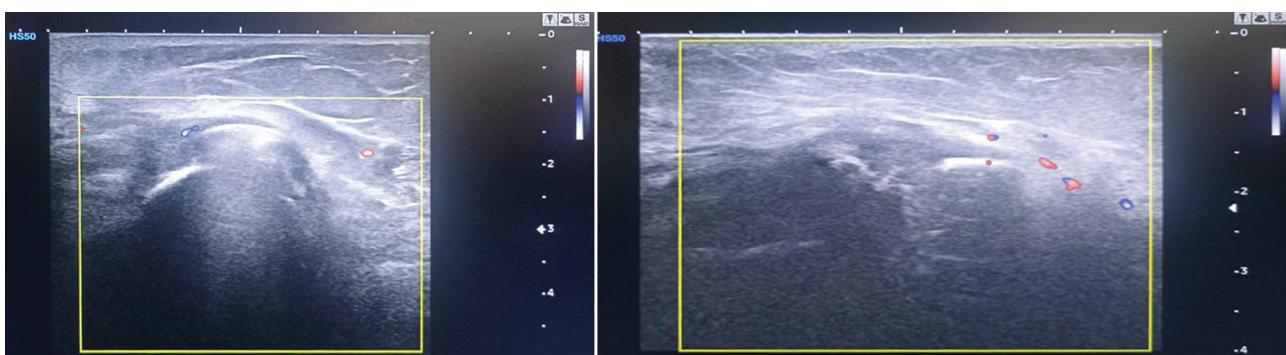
Ultrasound Dopplerography of the distal humerus fracture zone in a 42-year-old patient: 14 days and 2 months after surgical treatment
